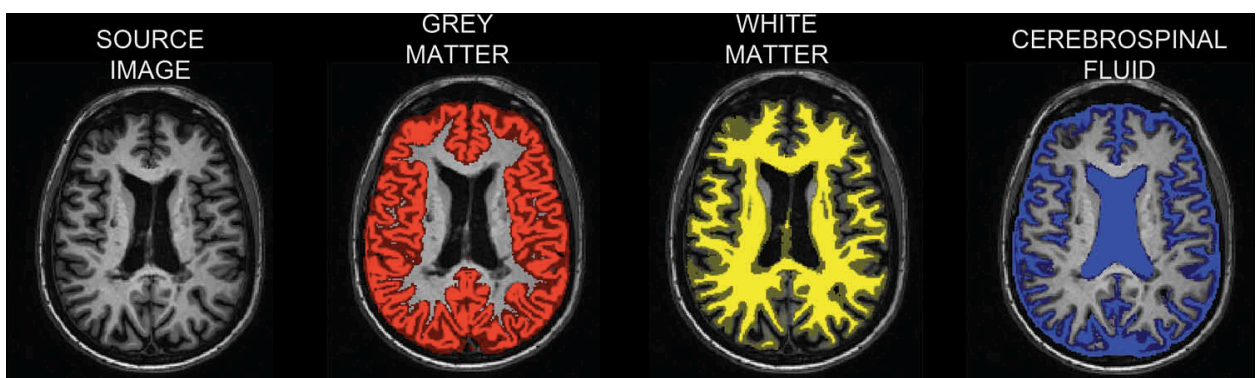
3D T1-weighted MRI scan from a patient with relapsing remitting multiple sclerosis (same slice, time point and patient as Figure 1). Periventricular T1 hypointense lesions ('black holes') evident on source image. Remaining images show automated segmentation of the 3DT1 scan into grey matter (red), white matter (yellow) and cerebrospinal fluid (blue). Figure from (Brown and Chard, 2016)
